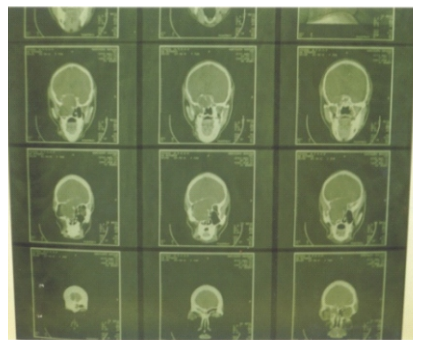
CT Scan of Patients with Tumours of the Nose and Paranasal Sinuses with Intracranial Extension
